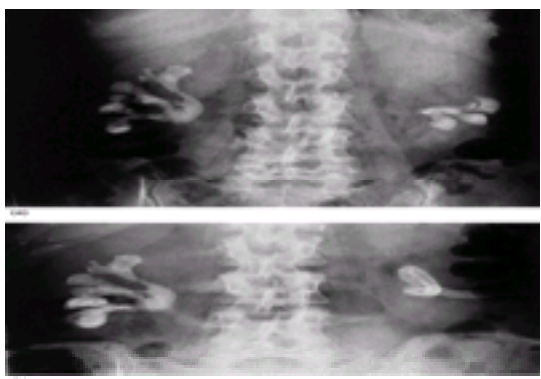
(a) A plain abdominal radiograph of bilateral staghorn calculi, the right being larger than the left. (b) The same patient following percutaneous removal of the left staghorn calculus: the nephrostomy tube is in place; the large right calculus remains.
